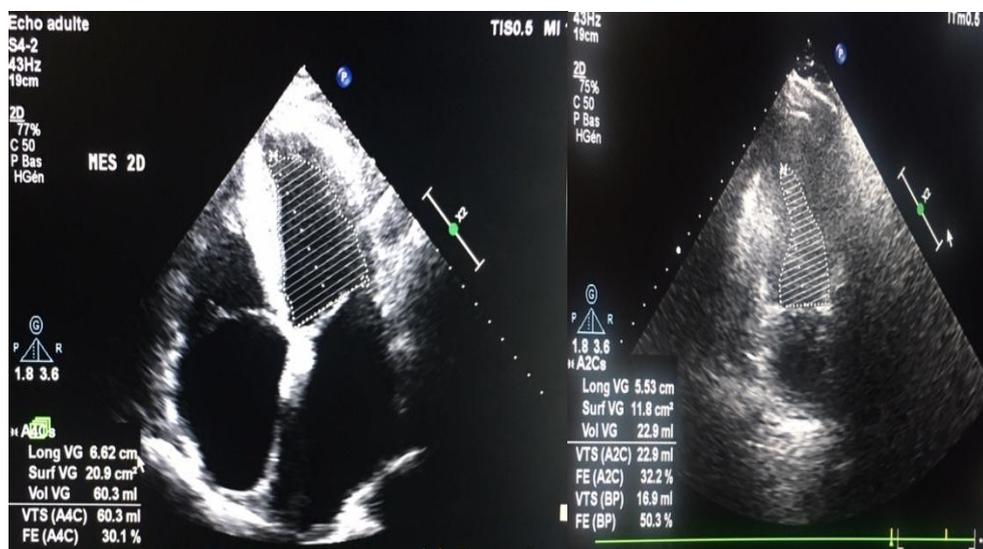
Ultrasound images of the initial left ventricular ejection fraction and its evolution of Case 1
